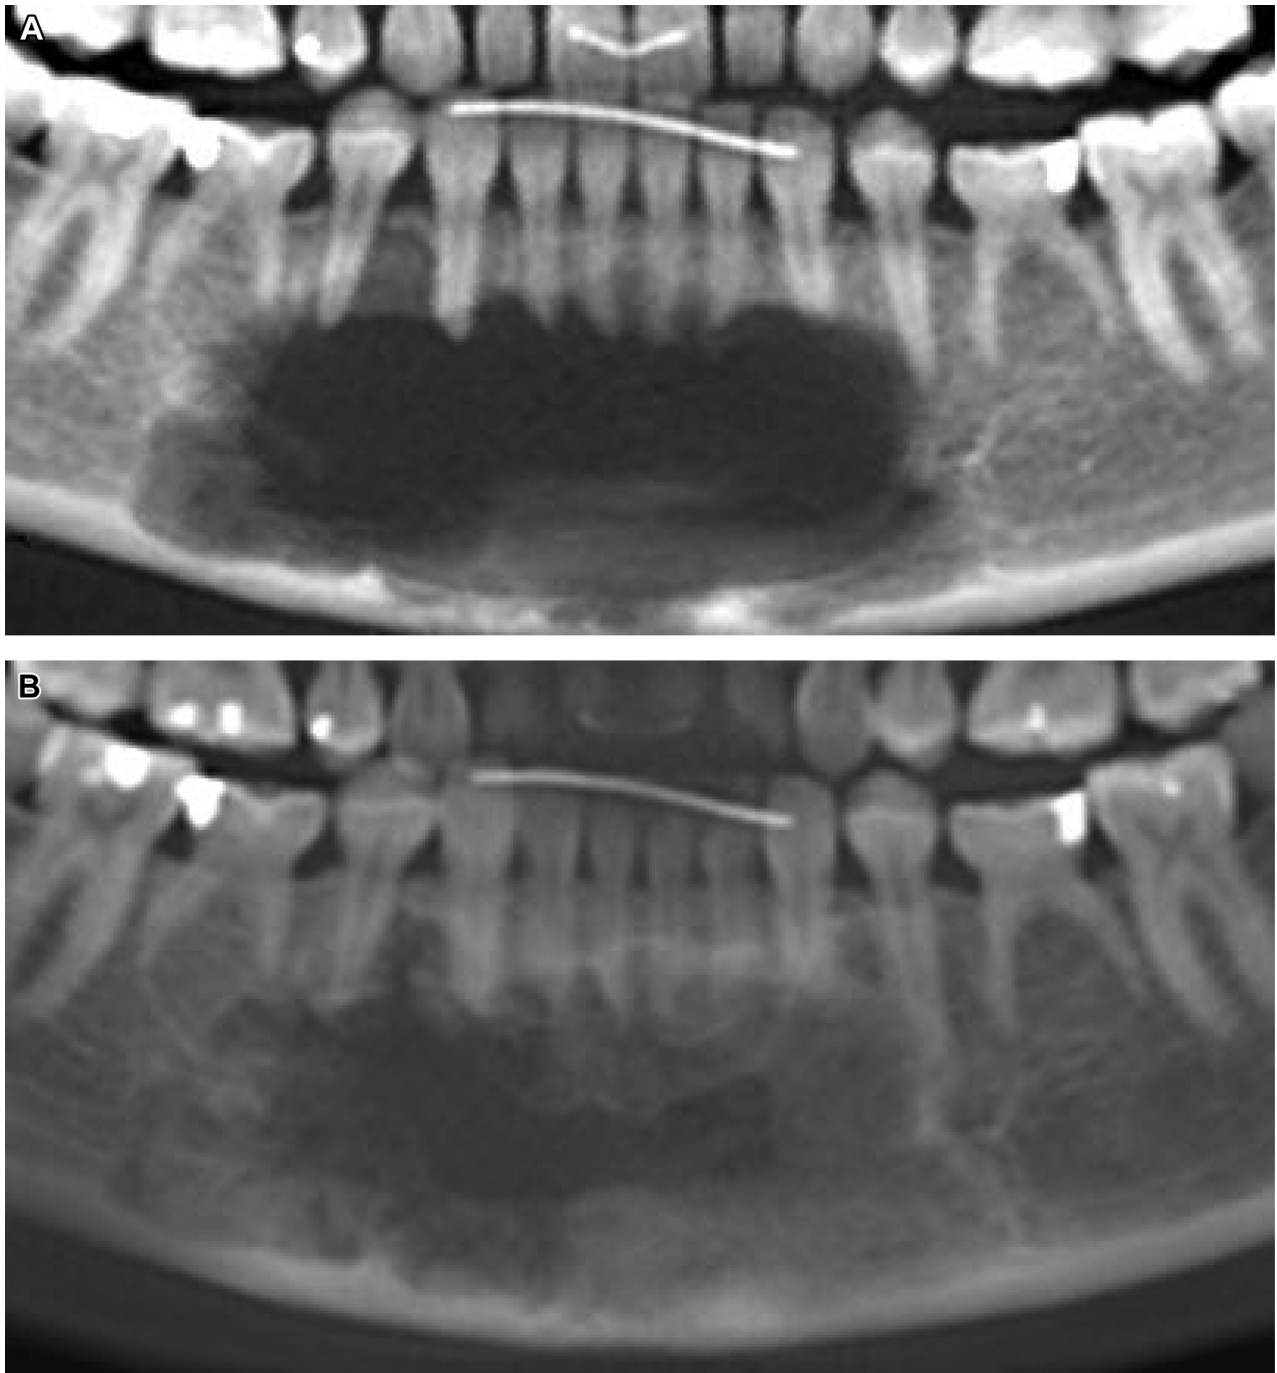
True-Pan cone-beam computed tomograms A, before and B, after 12 doses of denosumab.
